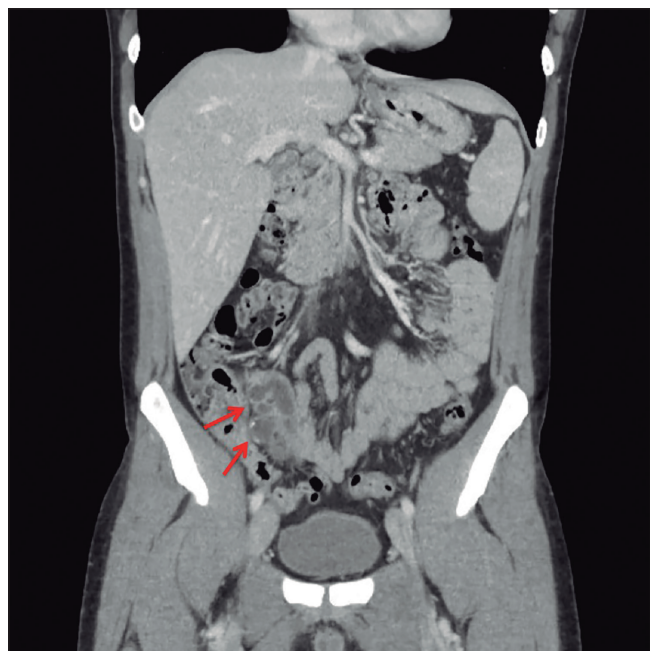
CT coronal reconstruction showing enlarged cecal appendix with thickened walls enhanced after IVC administration. Multiple saccular images are revealed on the appendiceal walls consistent with diverticula, one of them with thickened wall and slightly inflammatory changes nearby. Findings are compatible with appendicular diverticulitis.
